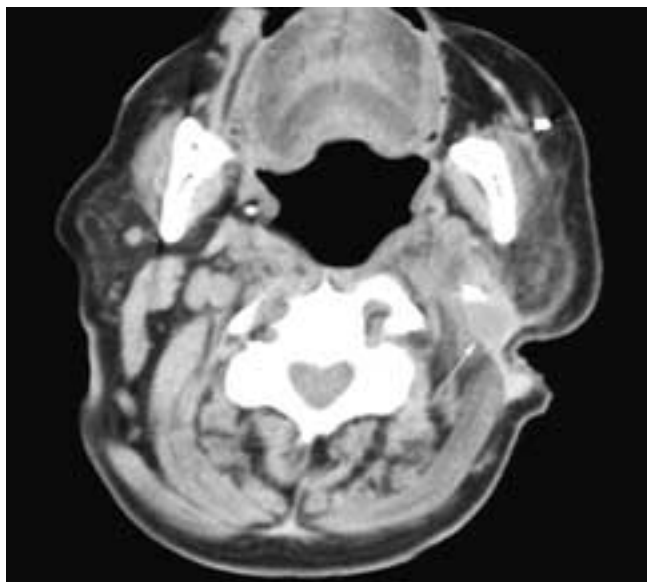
Axial contrast-enhanced CT scan on a patient who has had a left neck dissection shows a slightly low attenuation nodule (arrow) along the scar line. This was a postoperative traumatic neuroma.
